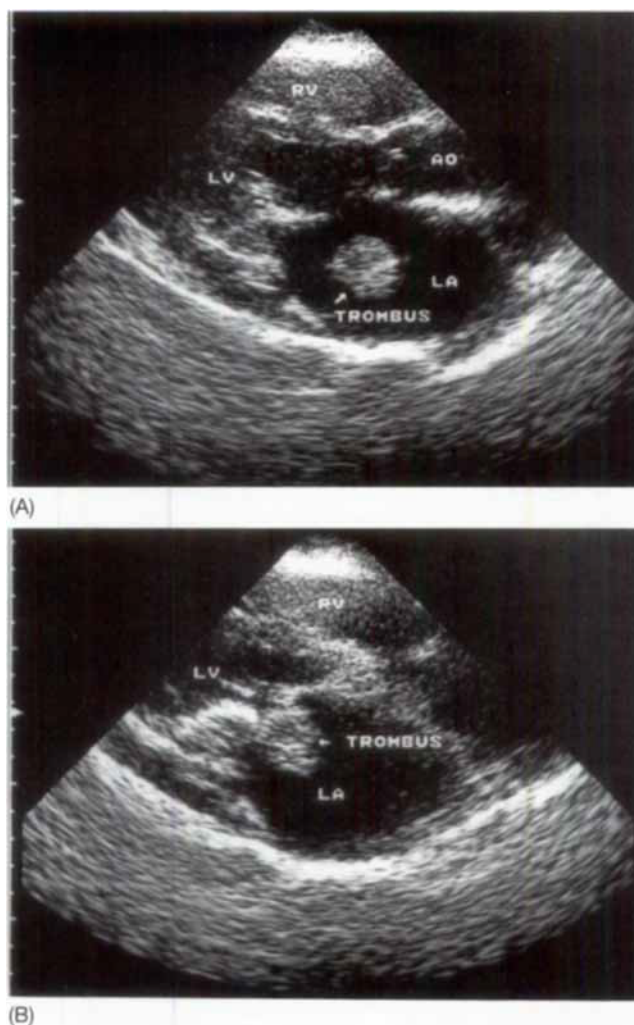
Parasternal long-axis view of the left atrium demonstrating different locations of the free-floating thrombus.
